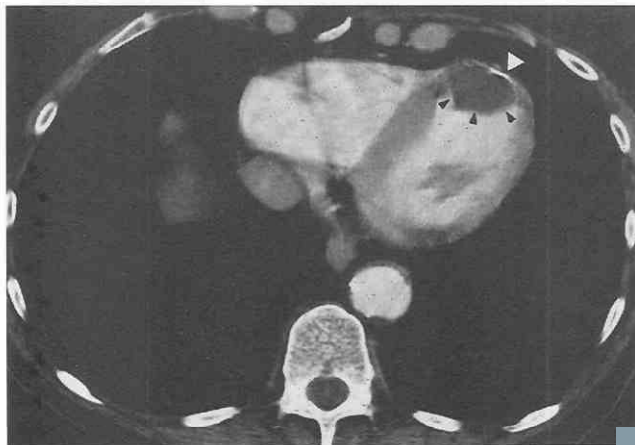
Calcified left ventricular aneurysm with apical thrombus. Contrast-enhanced CT shows a thin curvilinear calcification (*white arrowhead*) in the left ventricular apex, consistent with left ventricular aneurysm. Focal wall thinning and adjacent apical thrombus (*black arrowheads*) can be seen.
